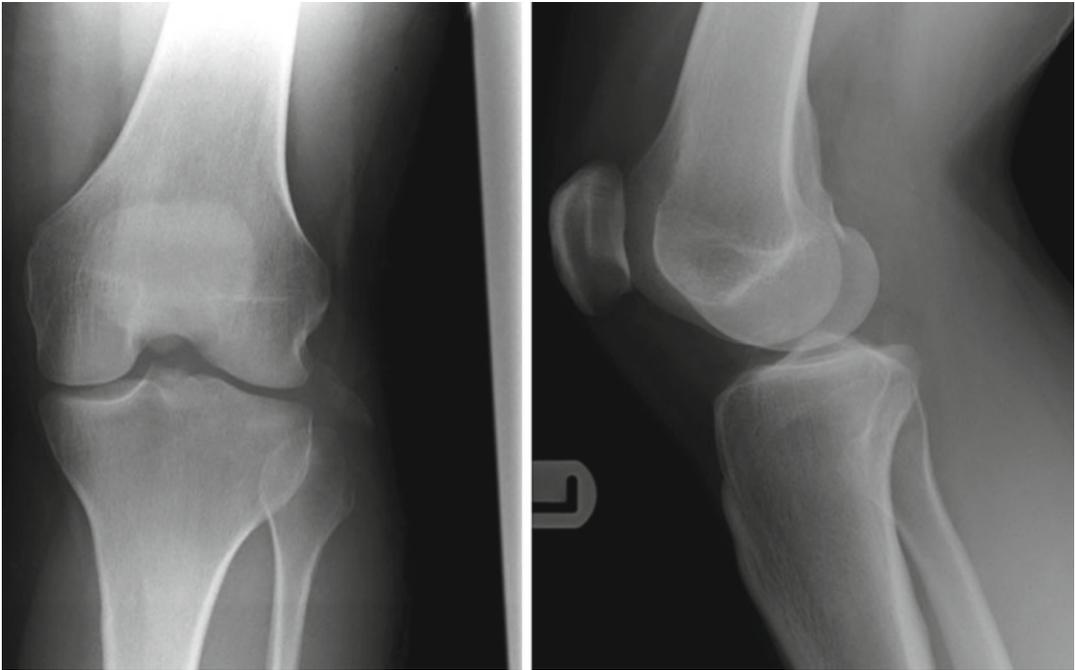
Frontal (*left*) and lateral (*right*) knee X-ray of the left knee of a 29-year-old woman who sustained a high-velocity motorcycle injury. The X-rays clearly depict the arcuate sign: an avulsion fracture of the fibular head
